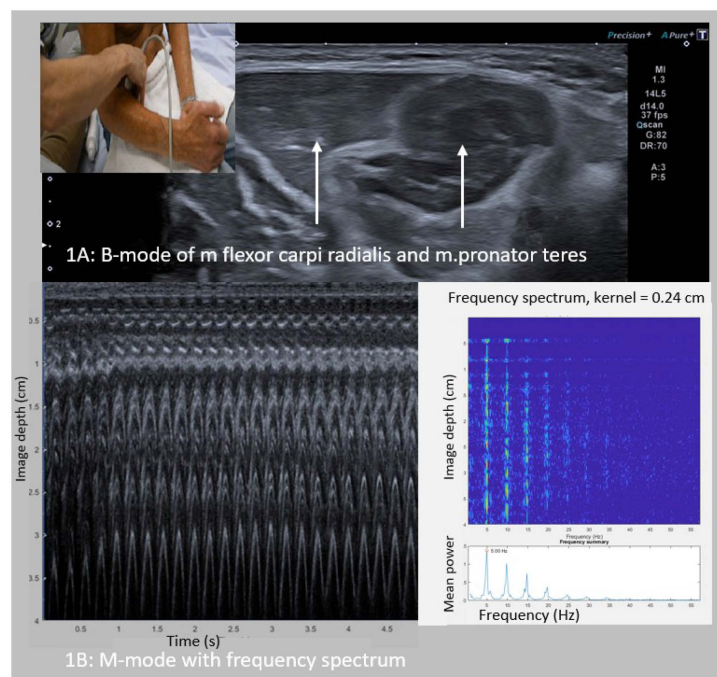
use of ultrasound in dystonic tremor:
